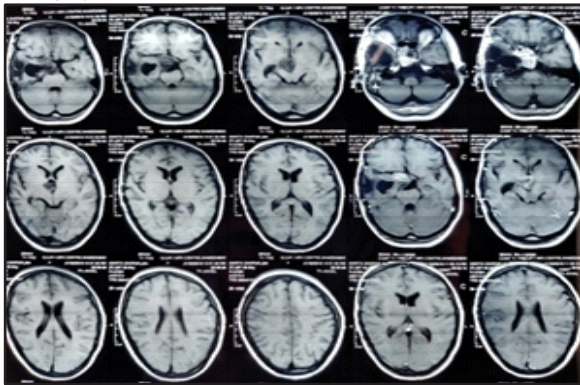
MRI brain at GCRI showing residual para-sellar mass
